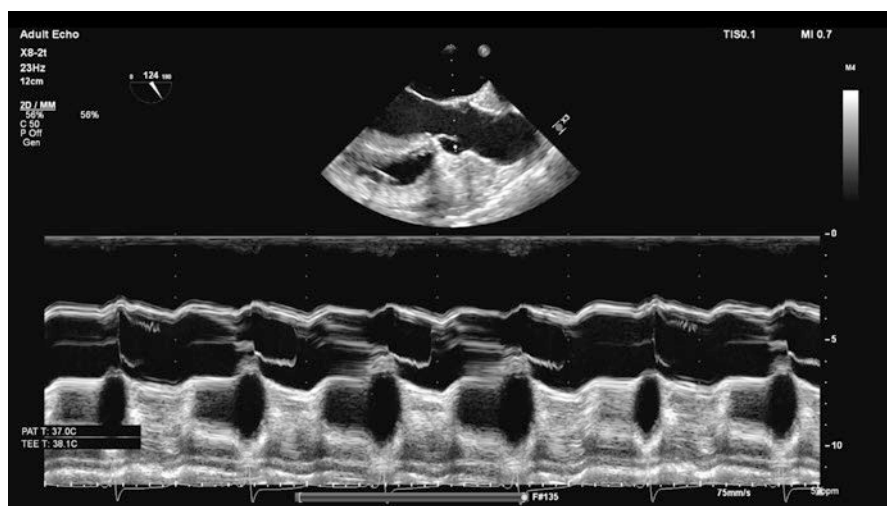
M-mode and B-mode. At the top of the image is the 2D echo image (B-mode) with the cursor directed across the aortic valve leaflets. Below is the M-mode tracing, demonstrating the density of all the structures through which the ultrasound beam is passing
